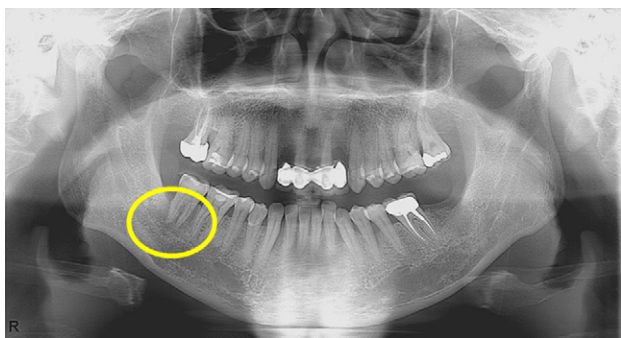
The circle indicates distal bone loss and a radiolucent shadow over the furcation area and the apex of the right mandibular 2nd molar (tooth 47) as examined by panoramic radiography.
